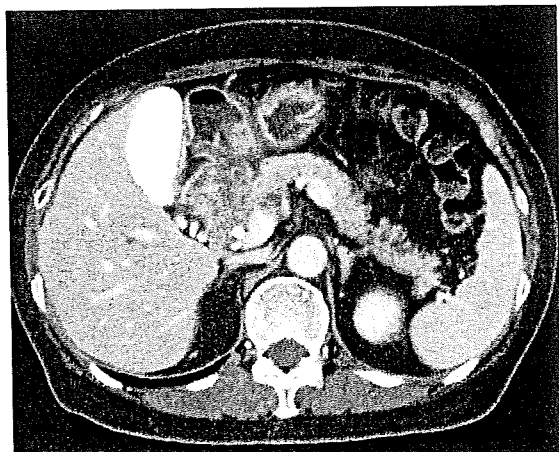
Abdominal computed tomography of Case 4 before treatment. The mass in the pancreatic head is contiguous with the duodenum and appears to invade the adjacent pancreatic tissue.
